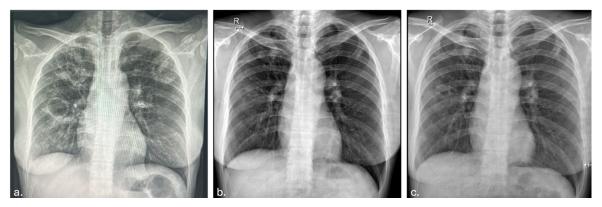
Serial chest X-rays: (a) Two months before treatment, (b) Three months after treatment, (c) Five months after treatment
